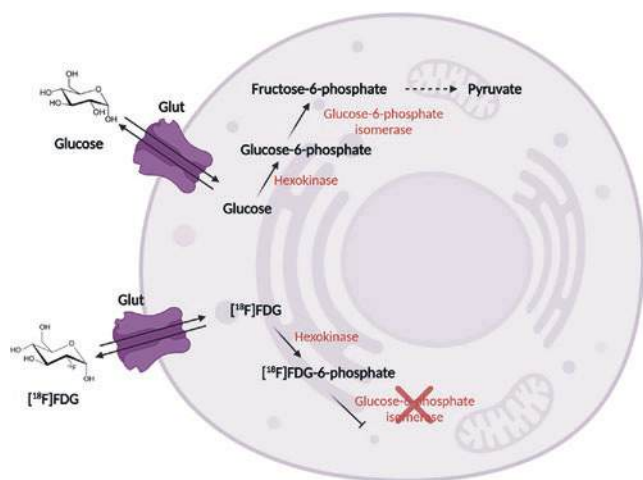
Metabolization of glucose and its radioactive analogue [^{18}F]FDG (Created with BioRender)
